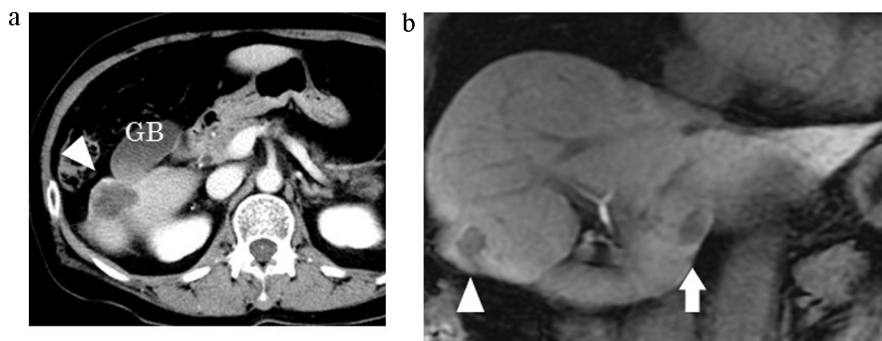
Imaging results. (a) Computed tomography shows a ring-enhancing 28-mm exophytic lesion (arrowhead) arising from S6 of the liver. GB, gallbladder. (b) Contrast-enhanced magnetic resonance imaging shows a signal-hypointense mass in S6. A similar small nodule (arrow) is apparent in S1.
